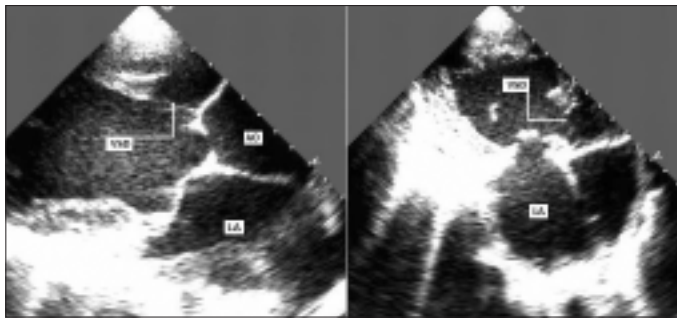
Two-dimensional echocardiography views of large membranous ventricular septal defect
